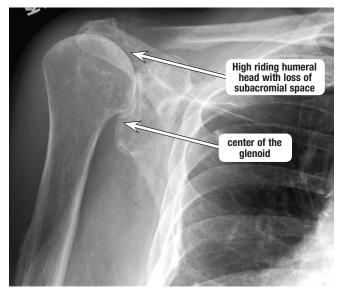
This is a radiograph of a patient with a chronic rotator cuff tear and rotator cuff arthropathy. Note the "high riding humeral head", you can notice the humeral head is significantly above the center of the glenoid fossa with loss of subacromial space.
